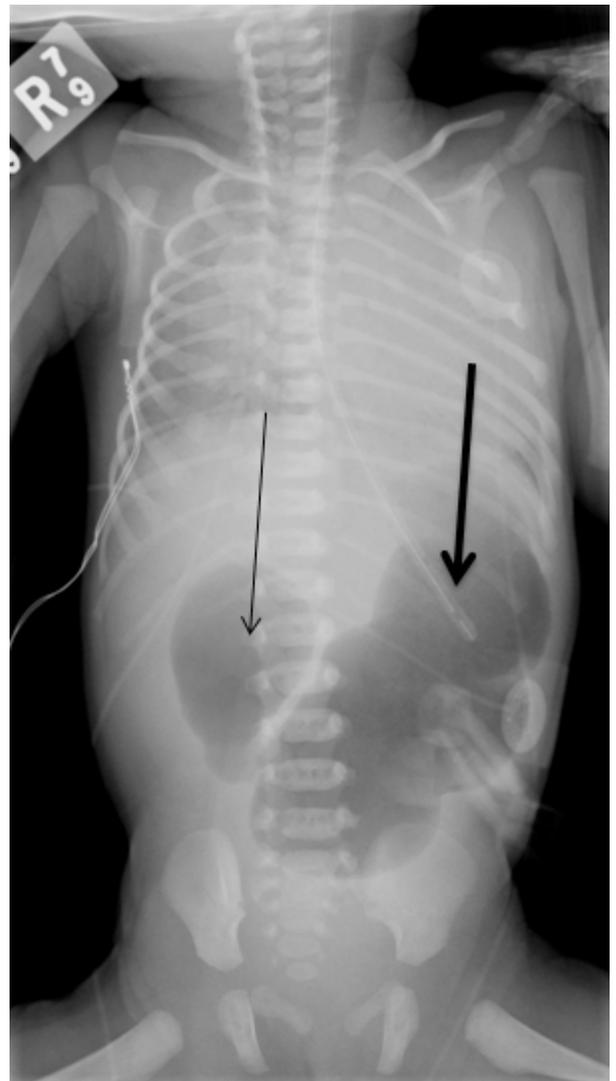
Abdominal radiograph demonstrating the classic "double bubble" sign associated with duodenal atresia (thick black arrow indicates the stomach, thin black arrow indicates the duodenum)
